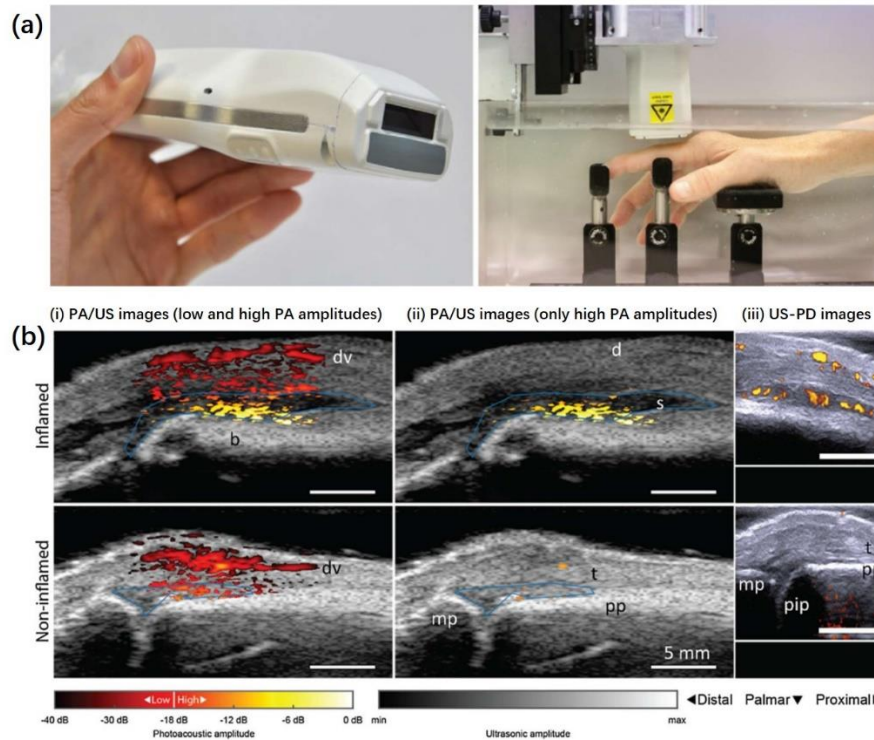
(a) The PA/US probe (left) showing the light delivery window (dark aperture). The patient's hand is submerged in water (right) where it rests on a series of supports. (b) PA/US and US/Power Doppler images of an inflamed (upper row) and non-inflamed contra-lateral joint (bottom row) of a rheumatoid arthritis patient. PA/US images in (i) show an increase in amplitude levels in the inflamed joint. When discarding low PA amplitudes as shown in (ii), only features in the inflamed joint are visible. Corresponding US/PD images are shown in (iii). d=dermis; dv=dorsal vein; pp=proximal phalanx; pip=proximal interphalangeal joint; mp=middle phalanx; s=synovium; t=extensor tendon.<sup>[15]</sup>
